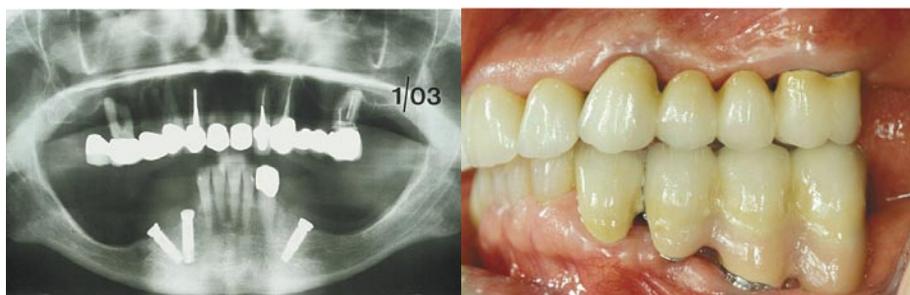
(a, left) X-Ray of two angulated implants which were inserted under atrophic bone levels without augmentation. (b, right) Fixed partial denture supported by one tooth and an angular implant.
